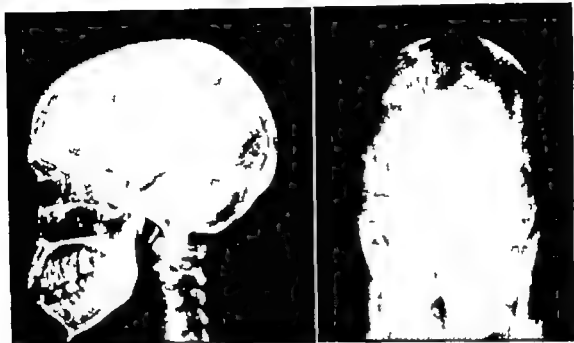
Sturge-Weber's syndrome. Skull roentgenograms of the patient in Fig. 242, showing hemispherical calcification of cerebral angiomas. (Courtesy J. C. Bielawski and M. Tatelman, *Am. J. Roentgenol.* 62:247 1949)
